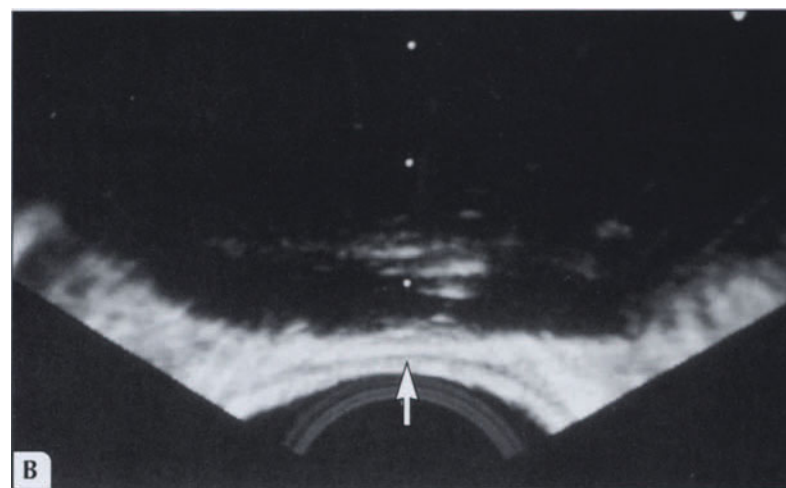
Freezing from the anterior portion of the prostate gland. Liquid nitrogen is circulated through the anterior probes, and the resulting freezing zones or “iceballs” are monitored by ultrasound (A). Once ice is formed inside the prostate, everything anterior to the ice is hidden by the acoustic shadow. Therefore, the anterior probes must be activated first.
